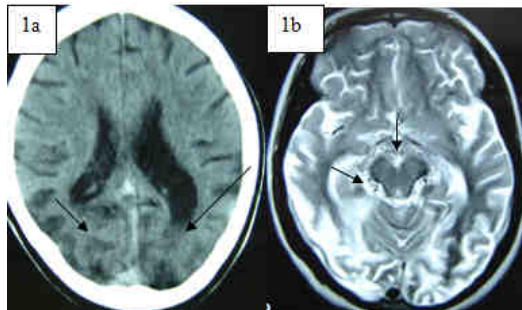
Brain CT shows bilateral parieto-occipital lobe infarcts (1a). Brain MRI shows flow voids around midbrain (1b)
